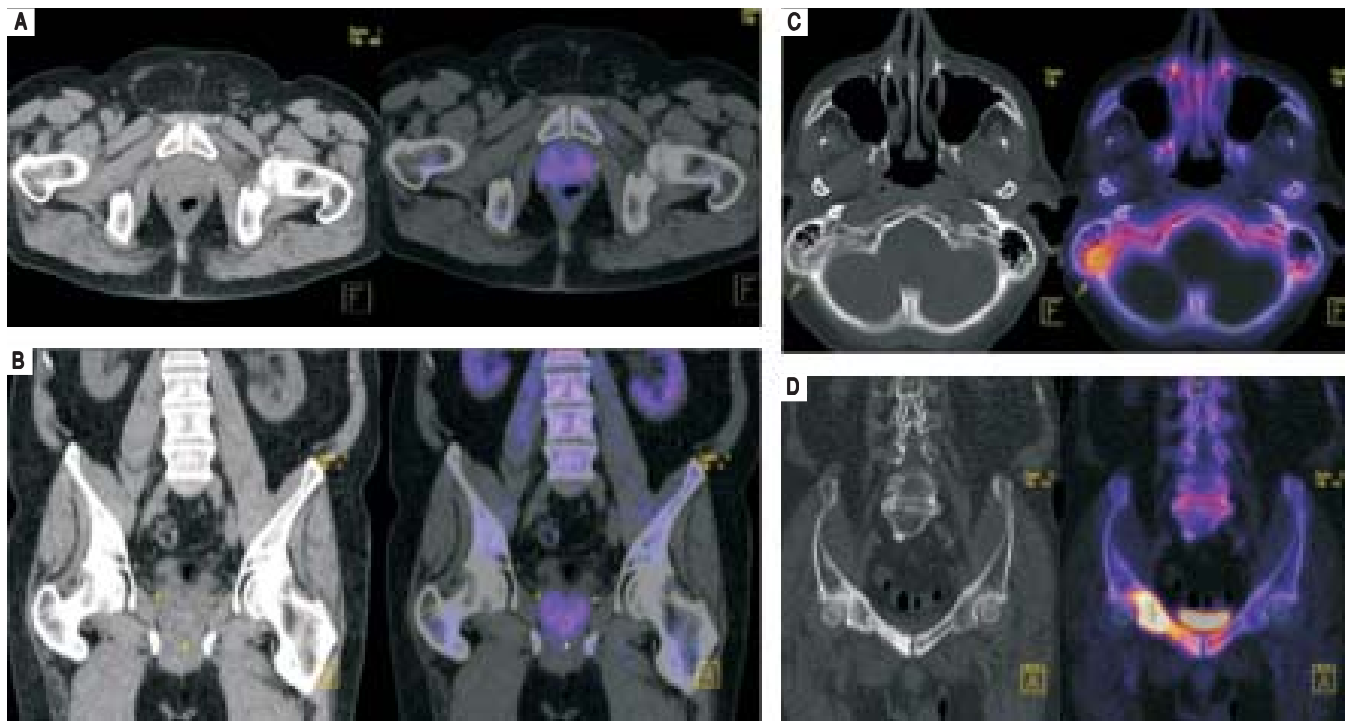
A-B. ^{11}C -Acetate PET-CT. 72 y.o. male with prostate cancer: High oxidative metabolism in a focal area of the prostate's left lobe. C-D. ^{18}F -NaF PET-CT. 77 y.o. male with blastic metastasis of prostate cancer: high NaF concentration in sclerotic lesions of the right mastoid bone and both superior pubic ramus, right predominant.
